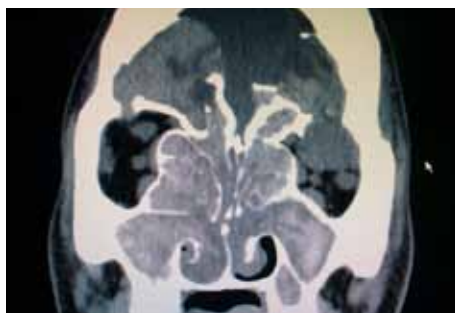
Preoperative sinus CT imaging
